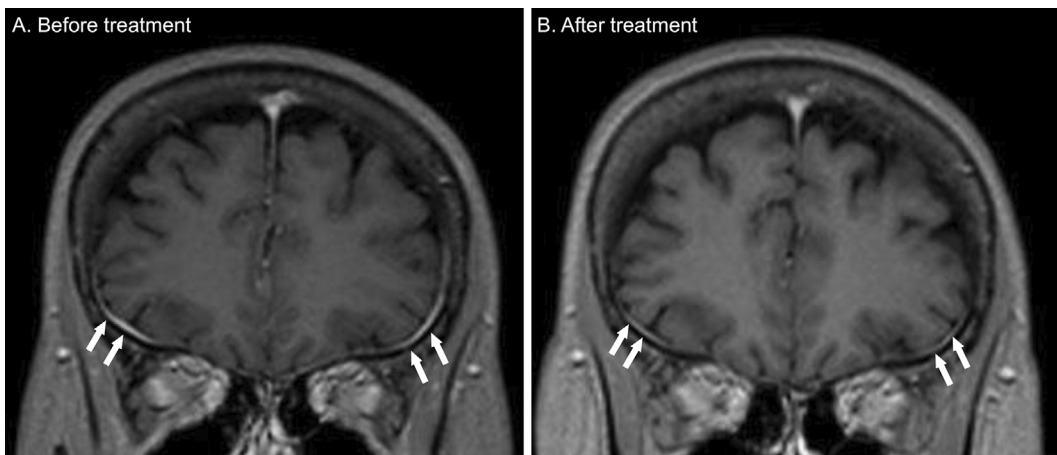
Coronal image of gadolinium-enhanced T1-weighted sequencing of brain magnetic resonance imaging (MRI) before (A) and one month after (B) the treatment. Dural enhancement were detected (arrows in A) and improved after the treatment (arrows in B).
